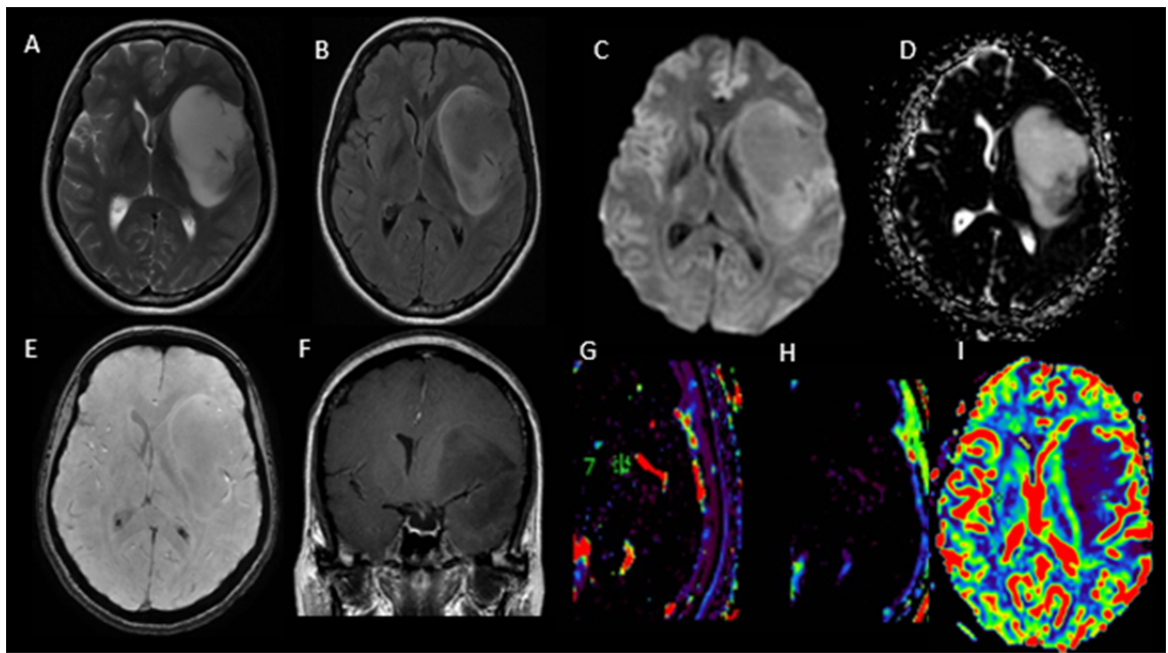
T2WI (A) and FLAIR (B) clearly demonstrate the FLAIR mismatch sign in the well circumscribed intra-axial mass lesion epicentred in the left insular region. Small area appearing hyperintense on DWI (C) and hypointense on ADC (D) , consistent with diffusion restriction is noted in the posterior part of the lesion. No areas of blooming are noted in the SWI (SWAN , E) images. The lesion shows no enhancement (F) , low values of k-trans (G) , V_e (H) and rCBV (I) on MR perfusion.
